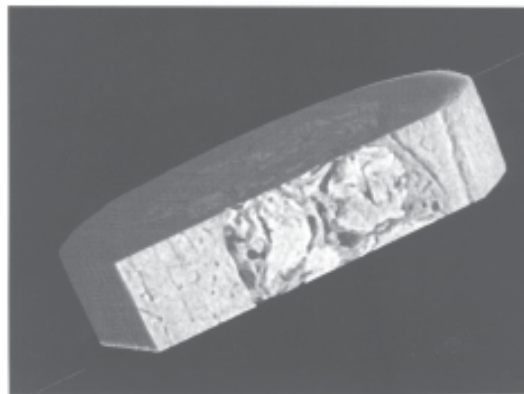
VGStudio Max software for 3D visualization of the reconstructed femur with Low Intensity Pulsed Ultrasound for Bone Augmentation
